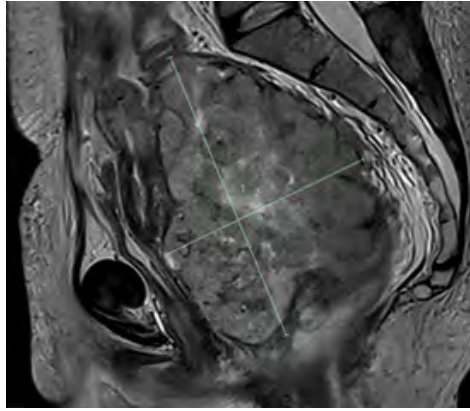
Magnetic resonance image scan pelvis T2 TSE sagittal demonstrating large cavitating fungating mass extending to the upper, middle and lower third rectum. Craniocaudal length is measured at 12.8cm and anterior posterior diameter is measured at 9.01cm T2 hyperintense foci in the lesion.
